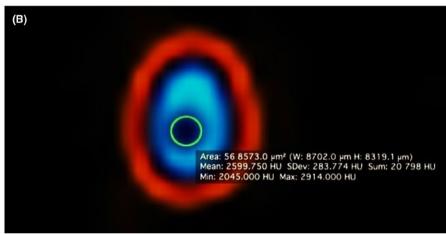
Representative cone-beam computed tomography images of preinstrumented canals visualized in the Osirix MD software. (A) Apical transportation (AT) measurement made before root canal preparation to be applied in the following formulae: AT= $(B_1-B_2)-(L_1-L_2)$ and $(M_1-M_2) (D_1-D_2)$, where B_1 and B_2 represent the values of the buccal root canal walls of the instrumented and uninstrumented root canals, respectively; L_1 and L_2 , the lingual root canal walls before and after instrumentation; M_1 and M_2 , the mesial root canal walls; and D_1 and D_2 , the distal root canal walls of the instrumented and uninstrumented root canals, respectively (B) Root canal area outlined in green to determine its limit. Change in root canal diameter (CRCD) measurement made before root canal preparation to be applied in the formula: CRCD=Fa-Ia, where Fa represented the final area, and la the initial area
